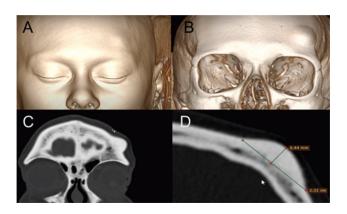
Radiological evaluation of the tumor. (A): 3D CT soft tissue surface. (B): 3D CT skull surface. (C): CT Coronal section showing the tumor. (D): CT horizontal section showing tumor measurements
